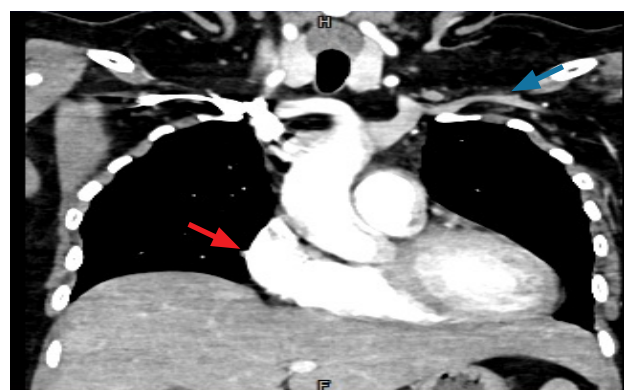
Follow-up coronal CT scan after 4 months of treatment, shows resorbed thrombus (blue arrow) and pericardial effusion (red arrow).
